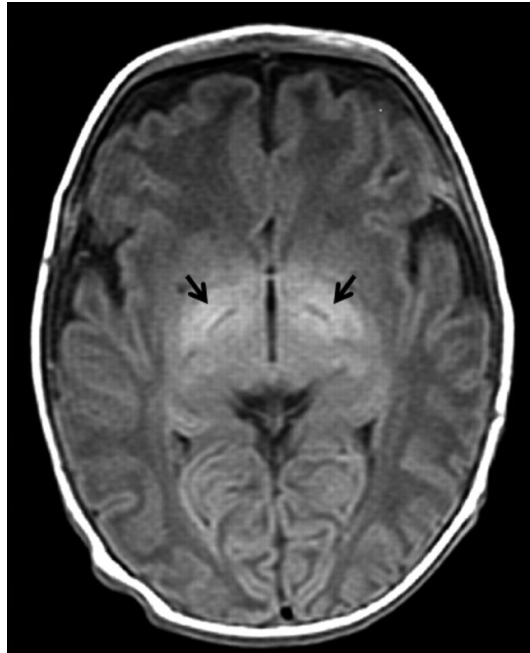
MRI brain showing hyperintensity in globus pallidus in T2 weighted imaging.
